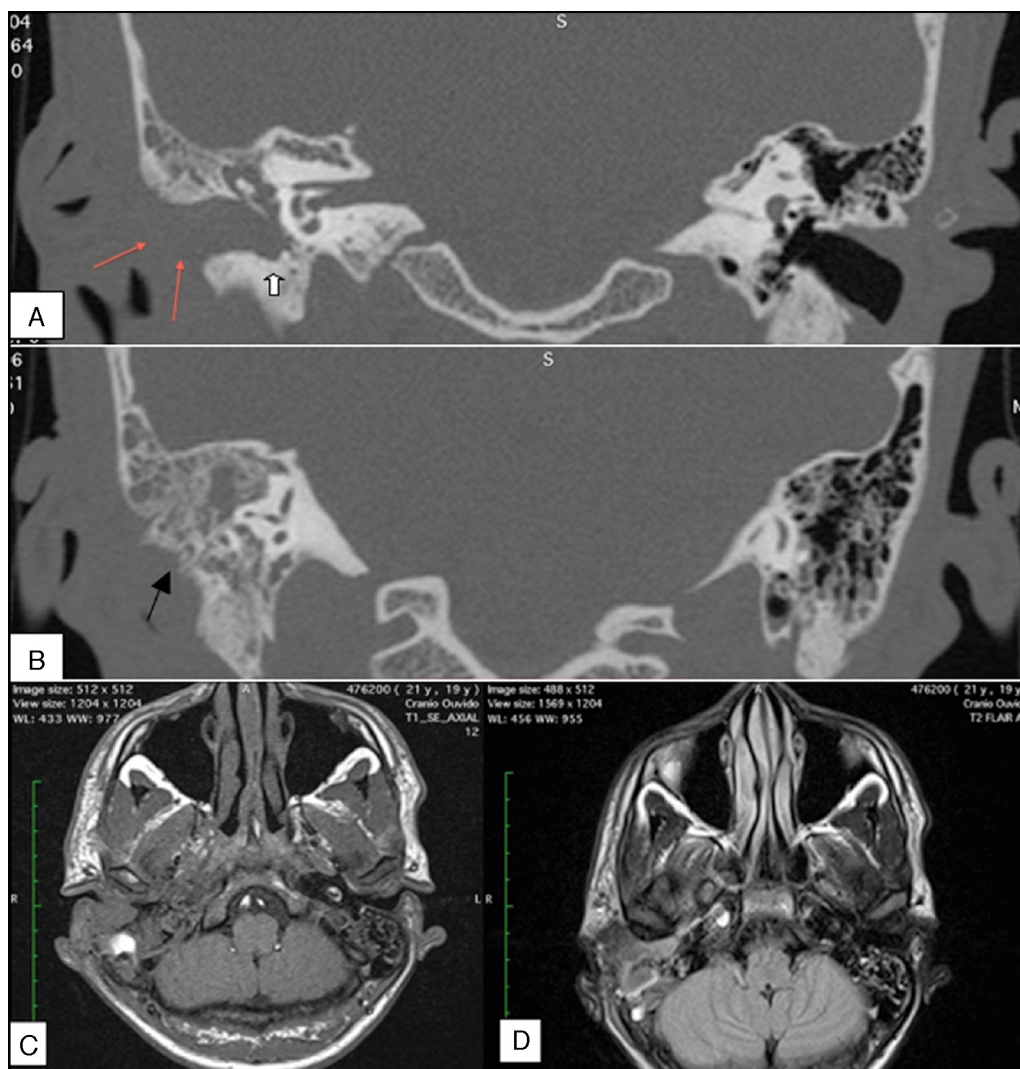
High-resolution coronal computed tomography images of the mastoids (A and B). (A) Erosion of the posterior wall of the external auditory canal (EAC; white arrow) and thickening and enhancement of the soft tissue in the region of the EAC (red arrow). (B) Erosion of the mastoid cortex (black arrow) and destruction of the bony septae. Magnetic resonance imaging of the mastoids (C and D). (C) Axial, T1-weighted image demonstrating infiltration of the soft tissues around the EAC, subcutaneous tissue, and parotid gland. (D) Axial, T2-Flair image showing the tympanic and mastoid cavity, with tissue contrast uptake spreading anteroinferiorly.
